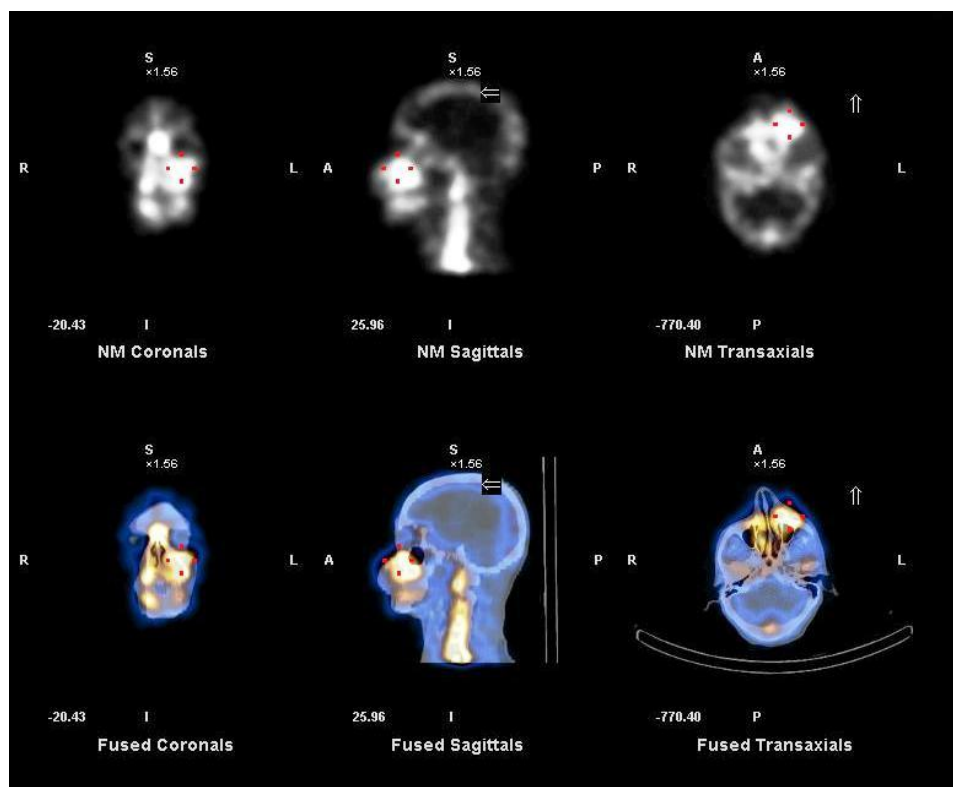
PET-CT showing increased concentration of FDG in left anterior maxillary region.
